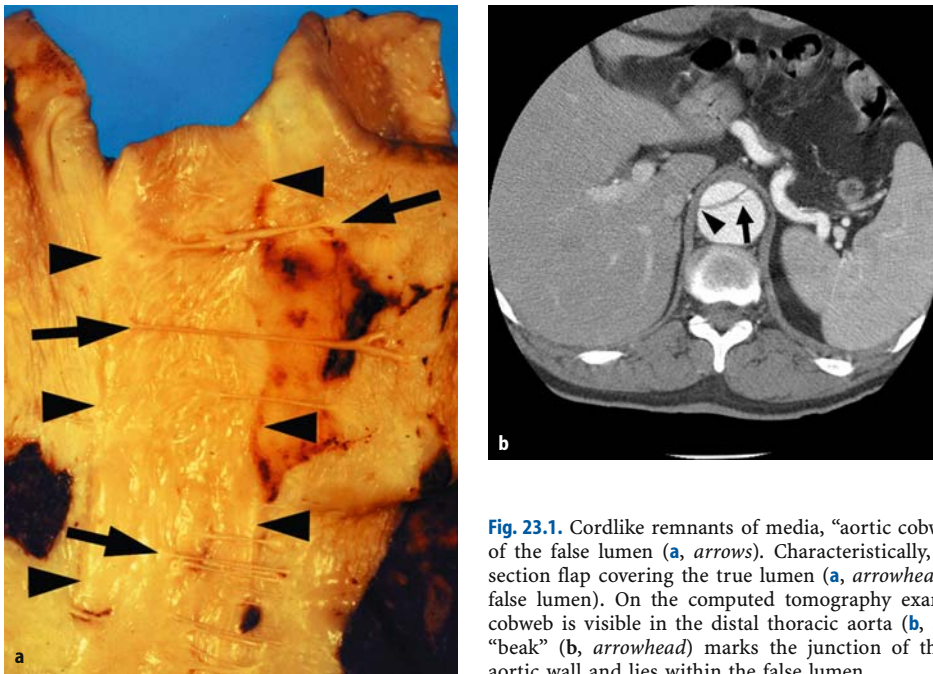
Cordlike remnants of media, “aortic cobwebs,” are a reliable marker of the false lumen (a, arrows). Characteristically, they stretch from the dissection flap covering the true lumen (a, arrowheads) to the outer wall of the false lumen). On the computed tomography examination of this patient, a cobweb is visible in the distal thoracic aorta (b, arrow). The acute angle or “beak” (b, arrowhead) marks the junction of the dissection flap with the aortic wall and lies within the false lumen
